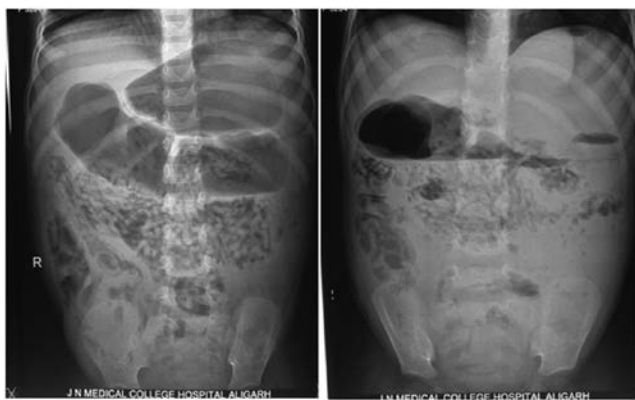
X-ray abdomen (supine and erect) of a child of 5 years of age with history worms infestation showing dilated small bowel loops and stomach gas shadow showing air fluid level with mottled appearance in most of the loops
